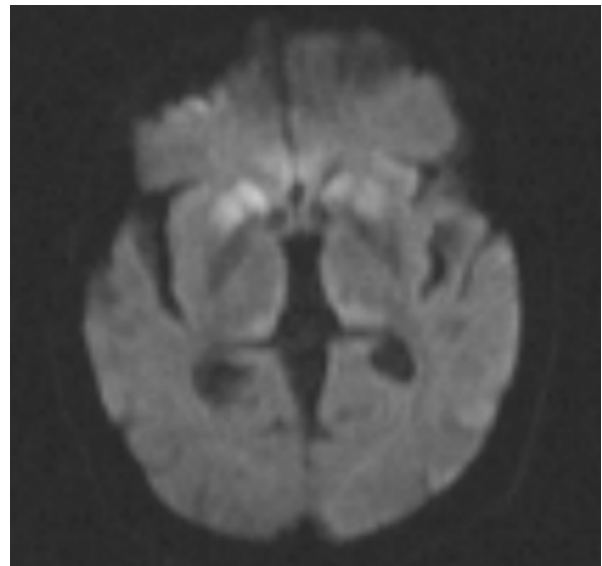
The following brain MRI shows compromise of putamen and caudate nucleus bilaterally, associated with hyperintensity of the anterior cingulate cortex and pulvinar and dorsomedial nucleus of the thalamus bilaterally. This corresponds to an infrequent pattern found in CJD and it is differentiated from the classical “double hockey stick” sign, present in the new variant CJD, by its lower hyperintensity compared with the caudate nucleus and putamen.⁽¹⁵⁾
